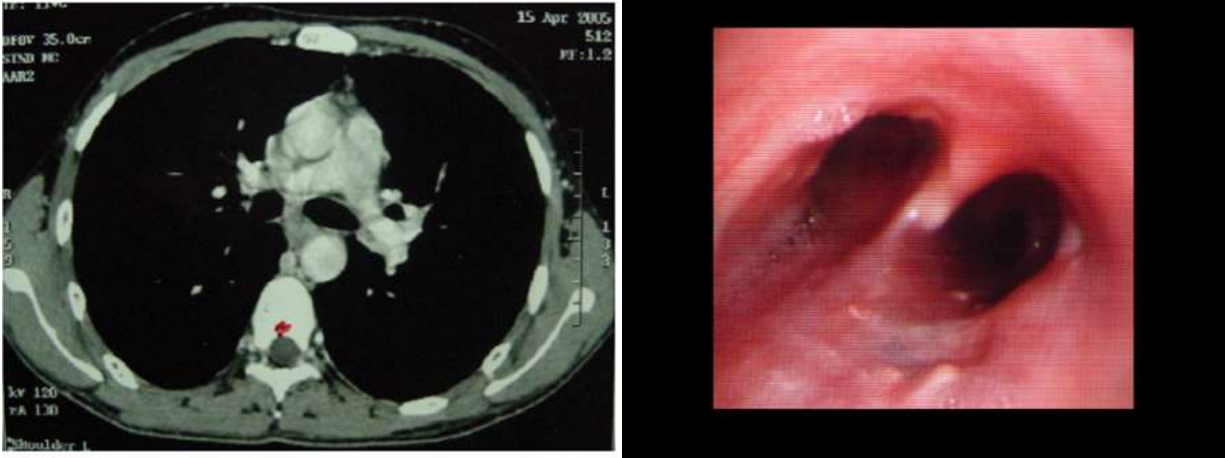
Computed tomography of chest reveals healing and closure of the fistulous tract after 2 months of Anti-tubercular treatment.
